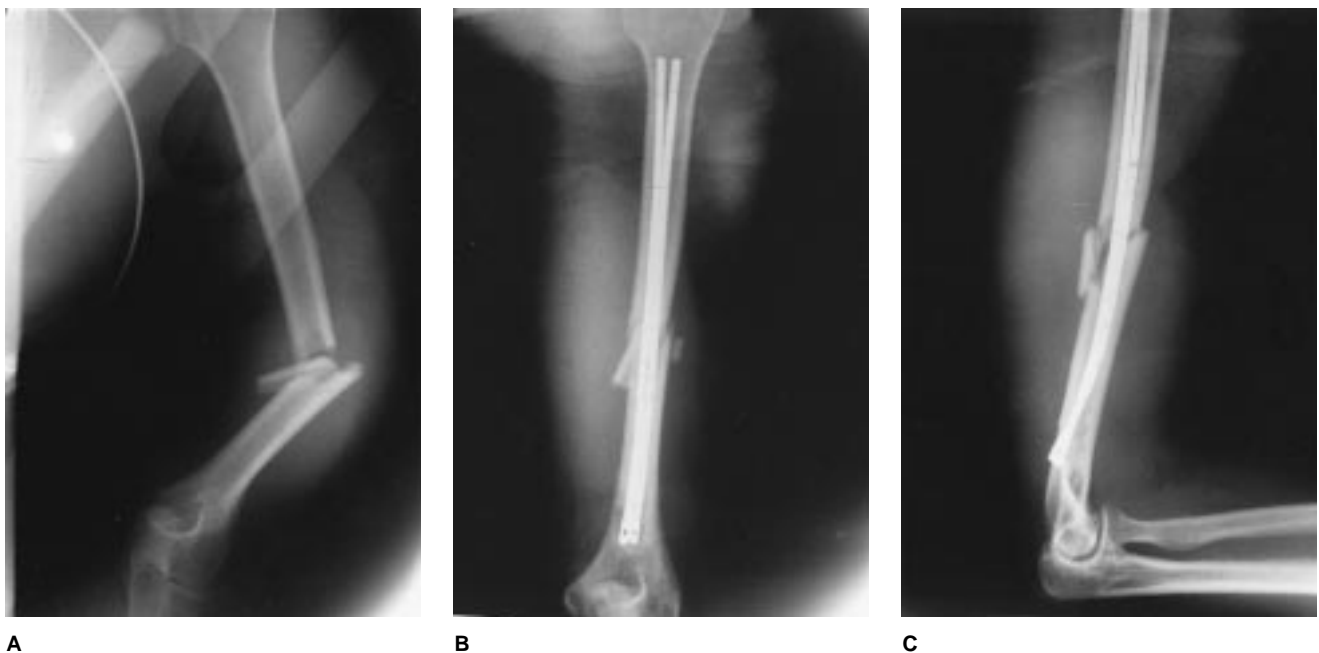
A, Anteroposterior radiograph shows humeral fracture in a polytraumatized patient. Anteroposterior (B) and lateral (C) radiographs show fixation of the fracture after retrograde placement of Ender nails.
